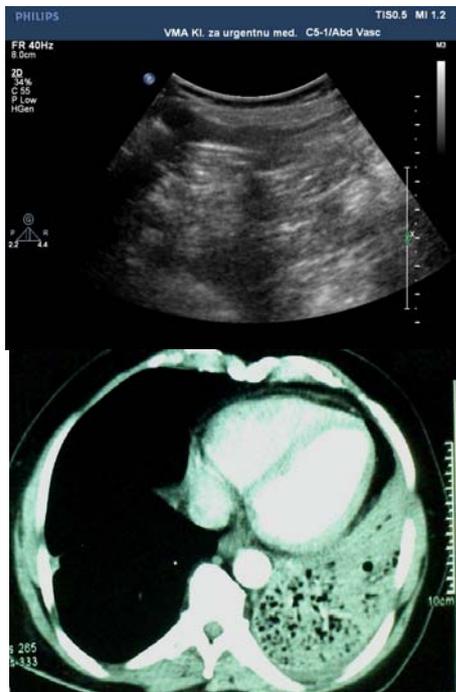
Pneumonia – parenchymal abnormalities in chest ultrasound and computed tomography (CT) scan: images reveal consolidation (alveoli are filled with fluid), as well as hepatisation – the lungs look like the liver; B-lines are visible in the inflammation area.
